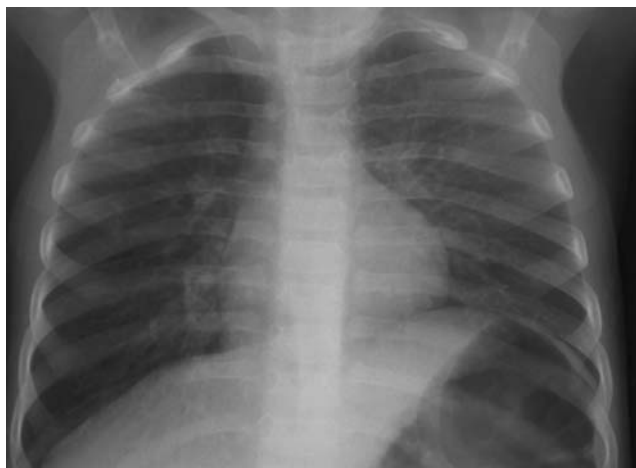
Posteroanterior chest radiography shows the hyperlucency and hyperexpansion of the right hemithorax
